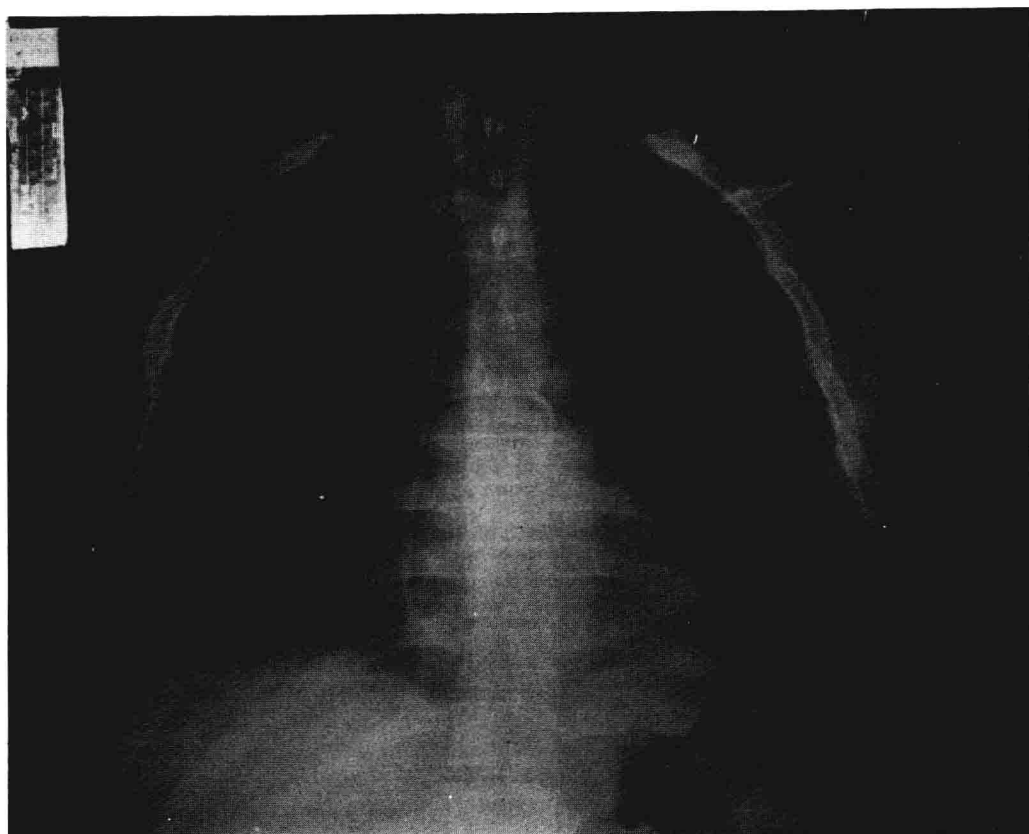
Roentgenogram of a Swan-Ganz catheter in position.
